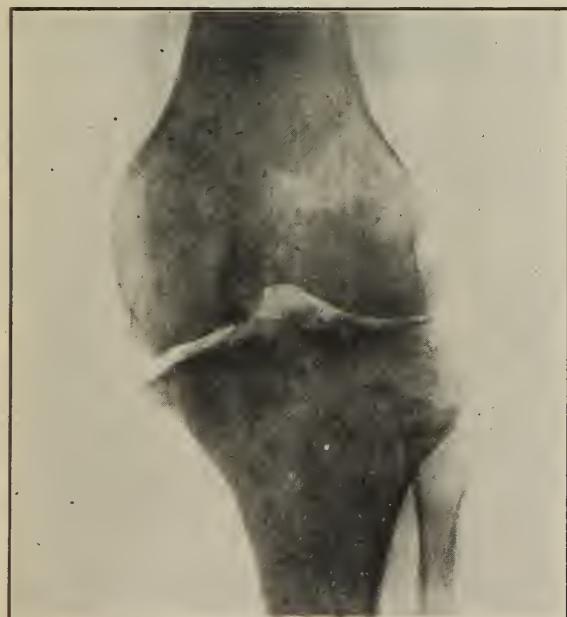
Case I, F. O'K. Antero-posterior roentgenogram twelve years after arthroplasty, January, 1923.
